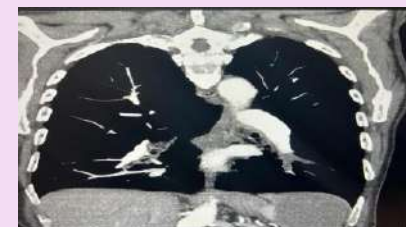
CT scan showing pulmonary embolism
